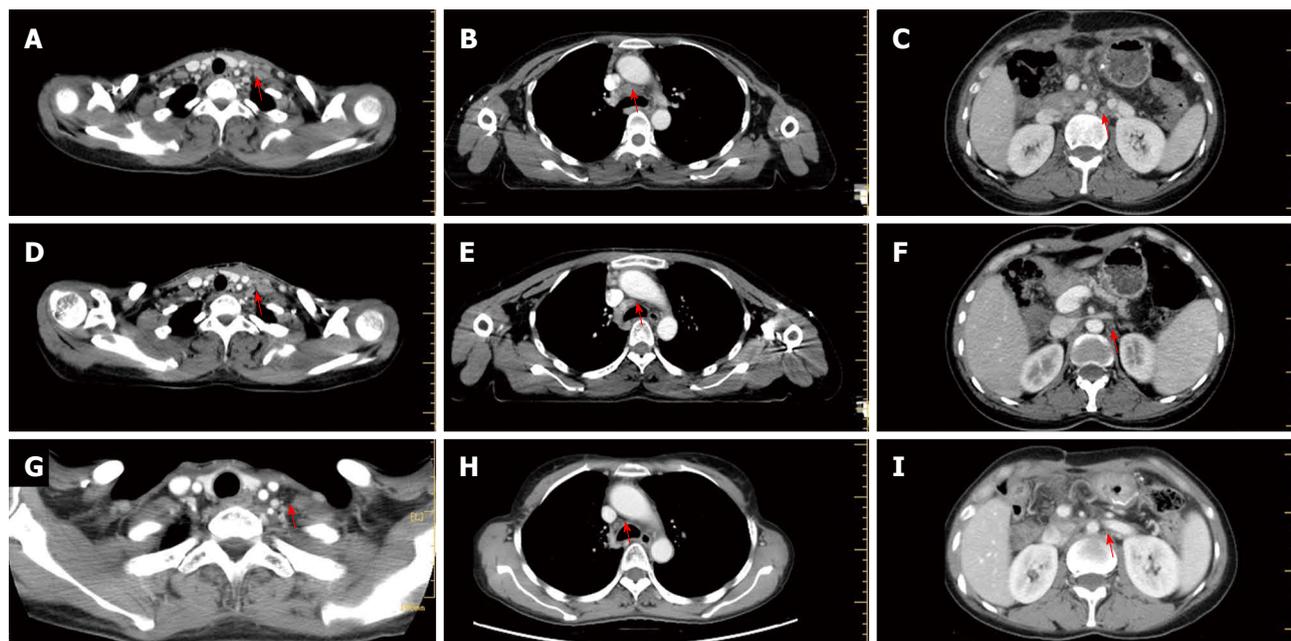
Computed tomography images of the recurrent lymph node metastases (red arrows). A-C: At the time of recurrence (A: Cervical region; B: Mediastinal region; C: Retroperitoneal region); D-F: Images taken 1.5 mo after chemoradiotherapy (D: Cervical region; E: Mediastinal region; F: Retroperitoneal region); G-I: Images taken 2 years after treatment (G: Cervical region; H: Mediastinal region; I: Retroperitoneal region). The recurrent lymph nodes dramatically decreased in size 1.5 mo after treatment, and nearly disappeared 2 years after treatment.
